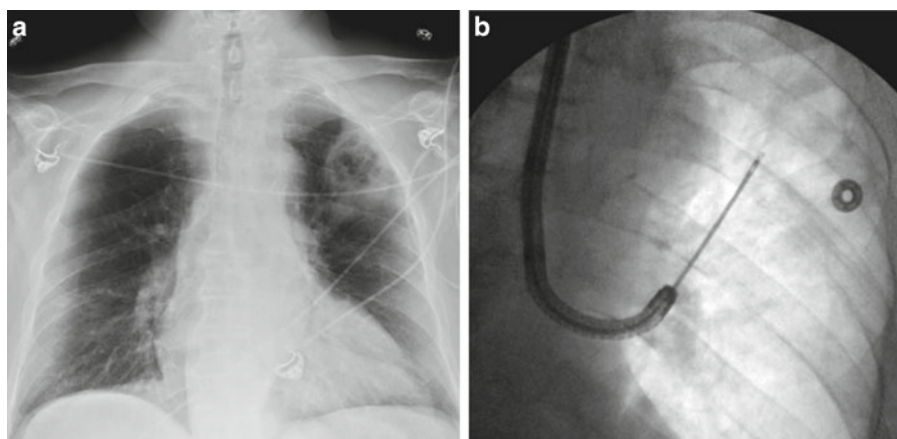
(a) Chest radiograph showing a left upper lobe cavitary lesion in an immunocompromised patient. (b) Transbronchial biopsy is obtained from the wall of cavitary lesion
